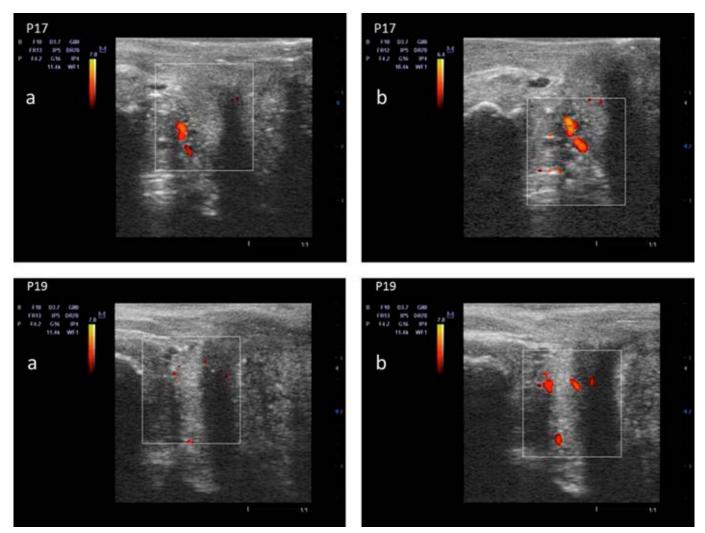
Example of a patient's Power Doppler at baseline and at one month after the last treatment session. a: Pre-treatment; b: At one month after the treatment.*
